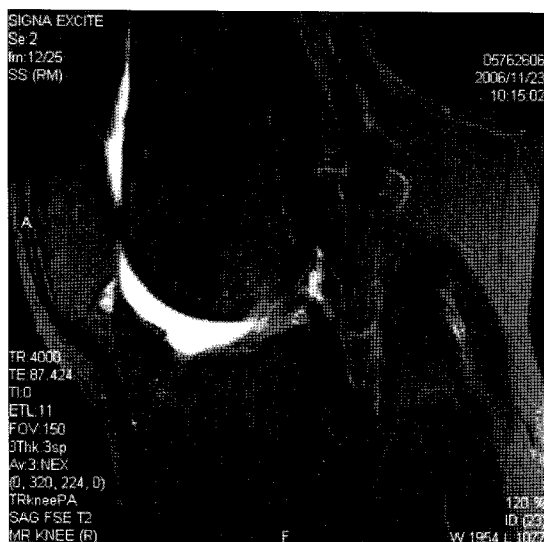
Six months after completion of radiotherapy. MRI shows marked improvement of synovial thickening and nodularity.
